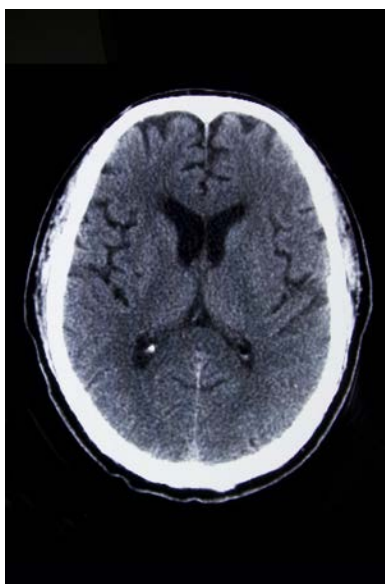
Middle portion of the brain axial CT image.
